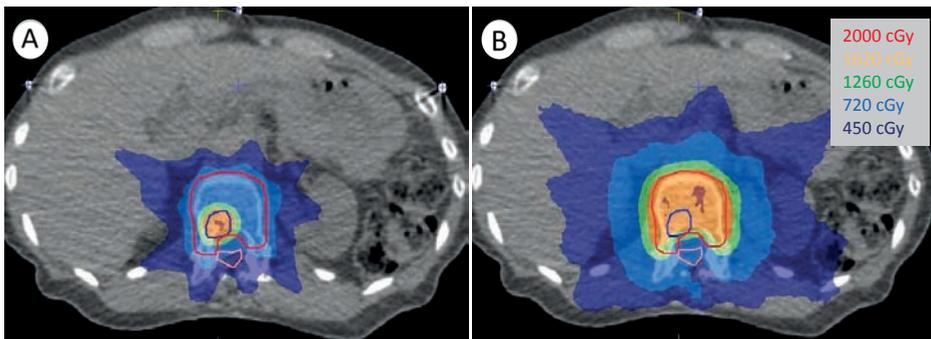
Delineation and planning for a representative case. (A) Axial planning CT slice showing the simultaneous integrated boost (SIB) SBRT dose distribution for a small metastasis in the L1 lumbar vertebral body. (B) The non-SIB SBRT radiation treatment plan that this patient would have been given without the SIB SBRT approach. In this patient, the dose to the elective surrounding relatively healthy bone was effectively reduced from 18.4 Gy to 10.9 Gy.
